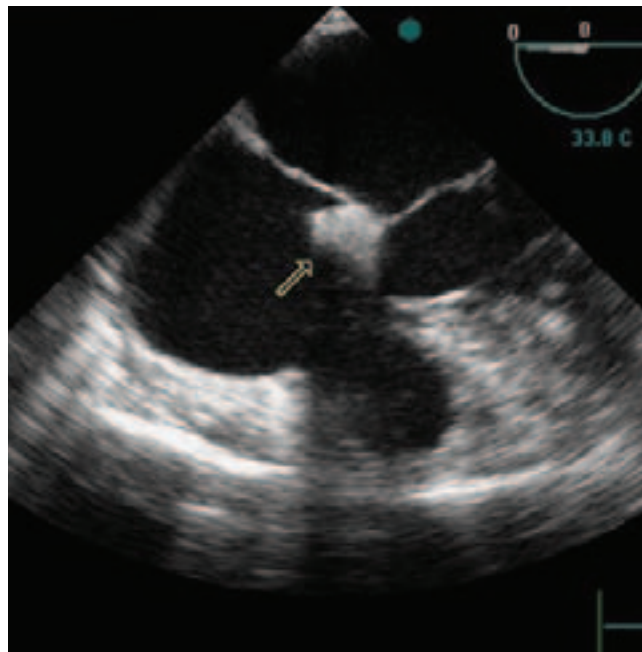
The Chiari network (arrow); transesophageal view
